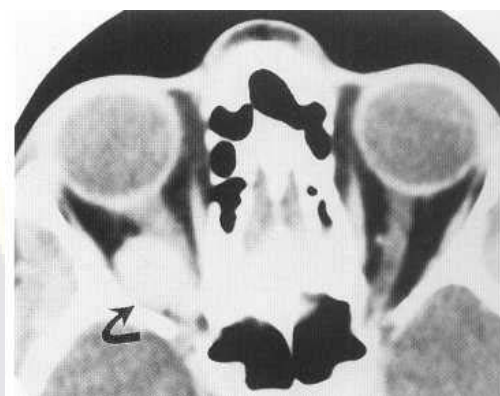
Neurinoma. Contrast-enhanced CT demonstrates medial displacement of right optic nerve by a well-circumscribed, homogeneously enhancing VIth nerve neurinoma. Note adjacent scalloping of sphenoid bone (arrow).
